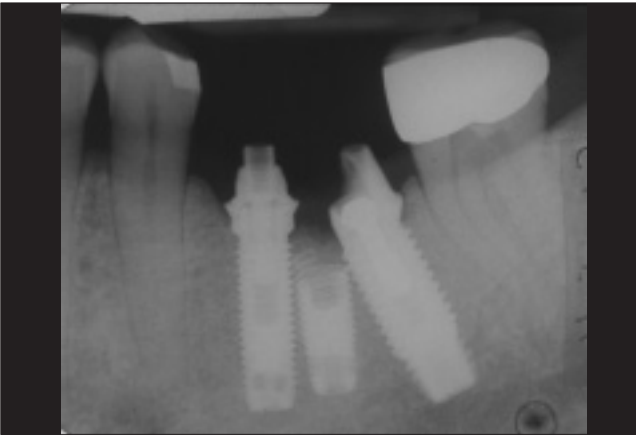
A periapical radiograph was taken at time of delivery to verify the abutments.
